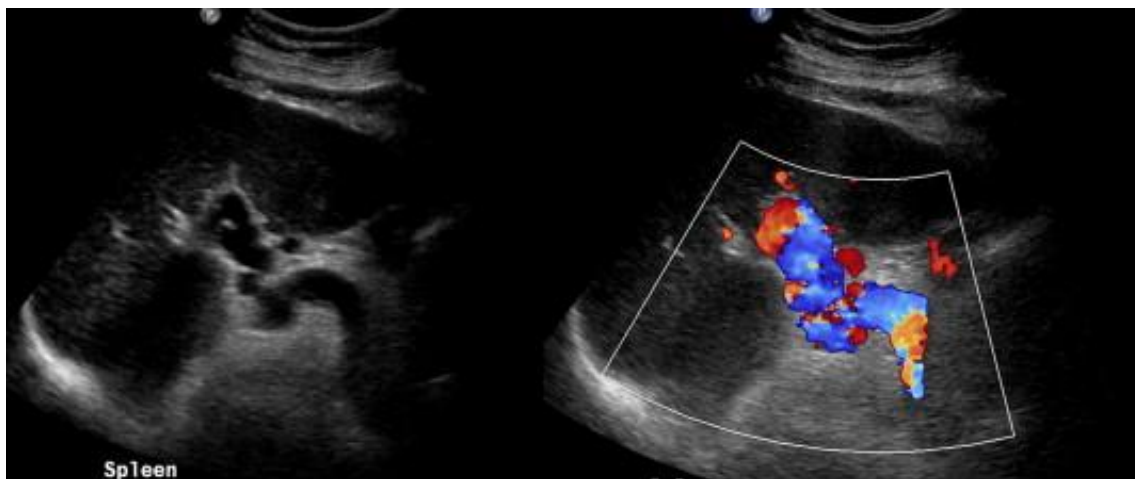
Grey-scale imaging showing an enlarged spleen, dilated splenic vein and splenorenal varices. Doppler imaging of the same patient confirms the presence of varices.
